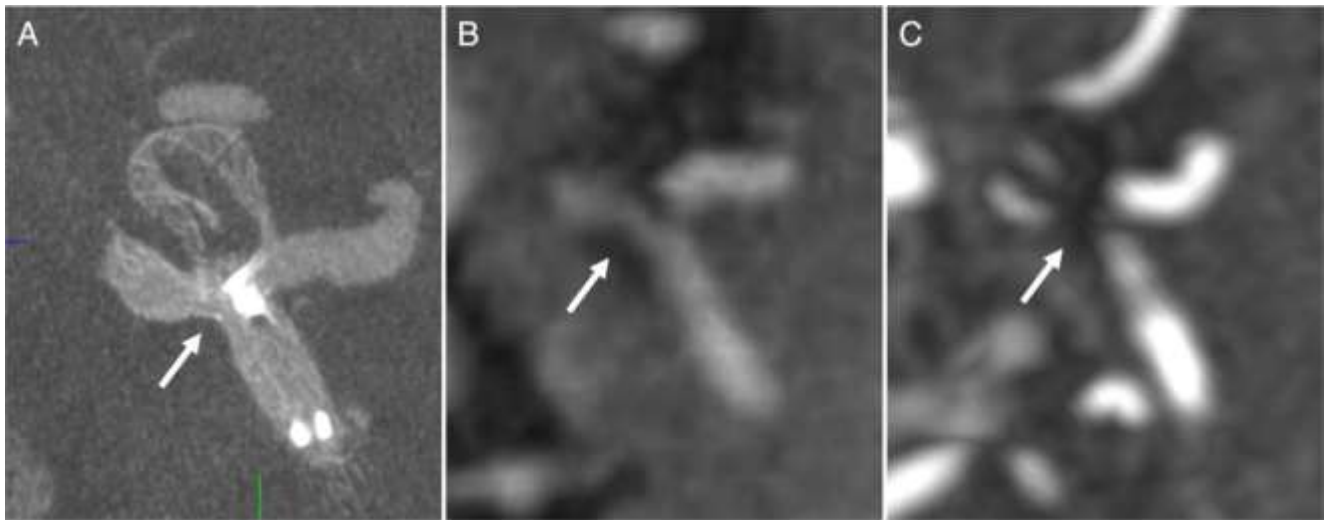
Example of an ACoA-Aneurysm treated with WEB and stent in the A1-A2 junction due to protrusion of the WEB after detachment. Note the visualization of the patent stent lumen in FD CT with intra-arterial contrast injection (A) and UTE MRI (B, arrow). In contrast-enhanced TOF MRA (C), the in-stent lumen adjacent to the proximal marker cannot be visualized (arrows).
